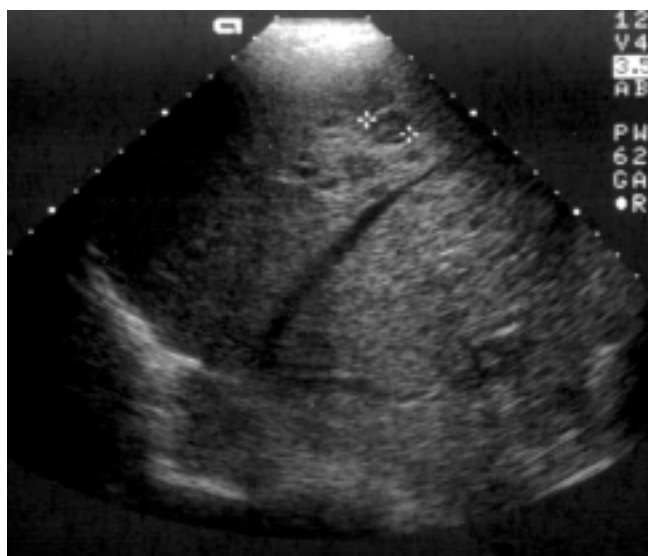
Liver ultrasound showing multiple small lesions of mixed echogenicity; secondary lymphoma.
